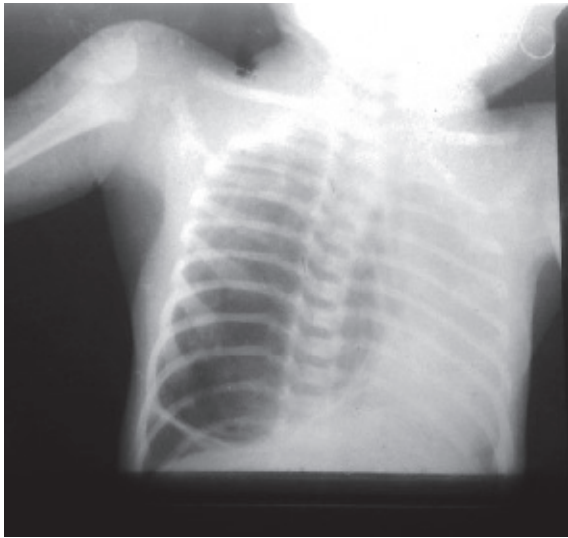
Infant, premature, Infant, low birth weight Chest X-ray of the child
